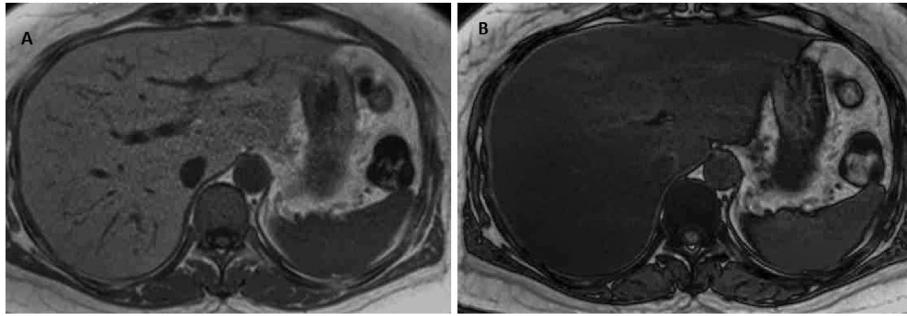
MRI Axial T1 in-phase image (A: diffusely increased hepatic signal intensity) and Axial T1 out -of-phase image (B: decreased hepatic signal intensity) show a significant decrease in hepatic signal intensity indicating fatty liver changes.
